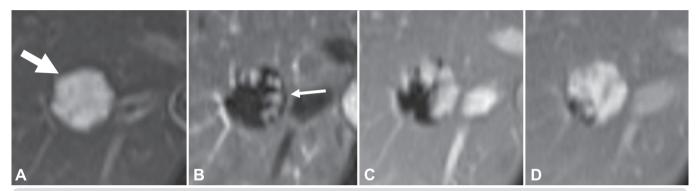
Type II hemangioma on MRI. A) T2-weighted image showing an hyperintense well-defined nodule (arrow). B) Arterial phase showing intense peripheric discontinuous nodular enhancement areas (thin arrow). C) On portal-venous-phase those nodular areas increase in size and tend to converge centripetally. D) On delayed phase the lesion tends to become homogeneously hyperintense, similar to the vessels.
